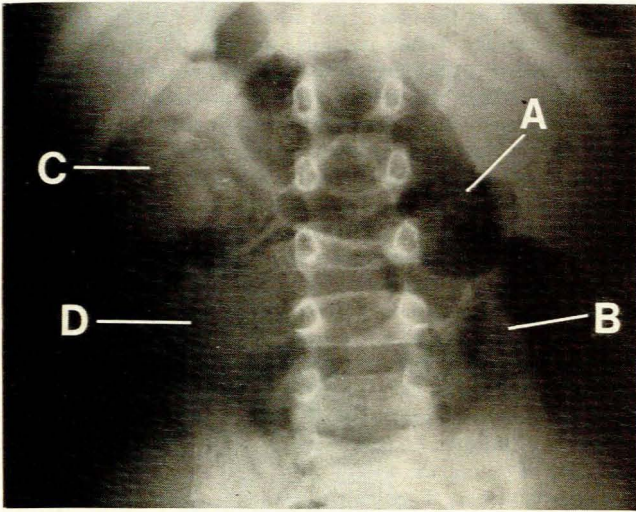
Abdominal radiograph showing several worm boluses: A — a convoluted mass of worms outlined by gas; B — a bolus containing linear radiolucent shadows sandwiched between two gas shadows distorting the medial one; C — this bolus contains multiple linear radiolucent shadows. The gas bubble below this outlines several worms and is distorted by this bolus and another (D) which contains several fine radiolucent gas bubbles.
